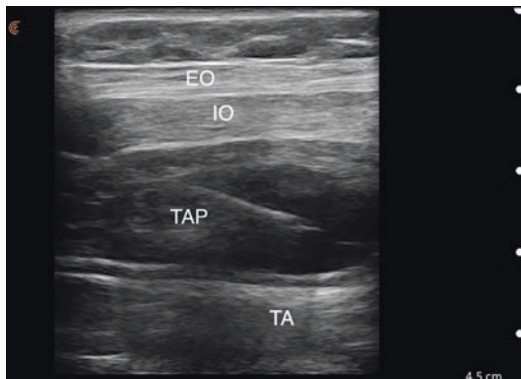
Grayscale ultrasound image of abdominal wall. Transverse view above umbilicus at the anterior axillary line. *EO* external abdominal oblique muscle, *IO* internal abdominal oblique muscle, *TA* transversus abdominis muscle, *TAP* transversus abdominis plane. Anechoic spread of local anesthetic in TAP
